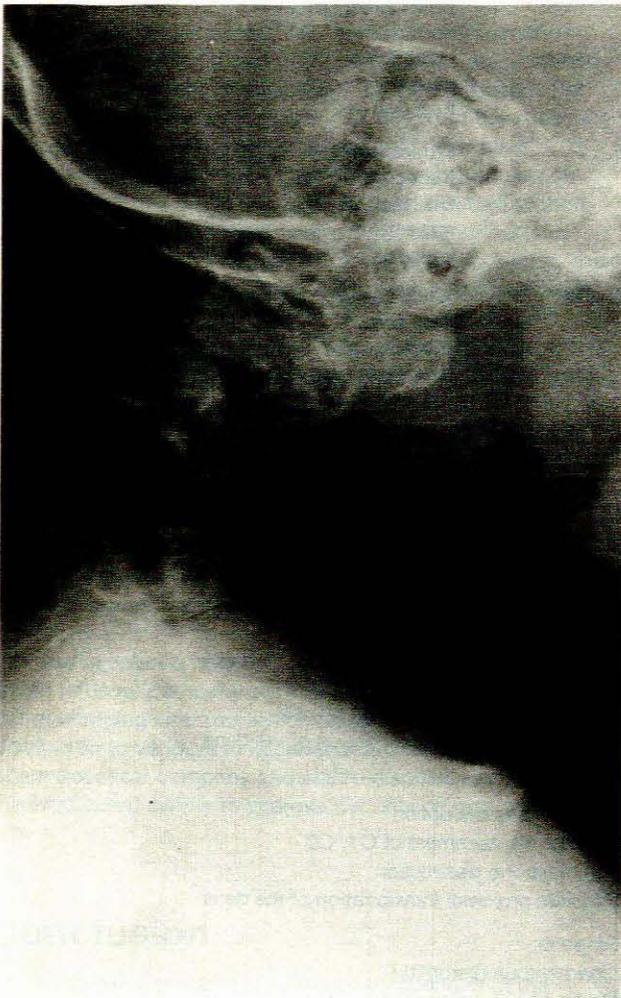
Case 6. Radiograph showing severe prevertebral soft-tissue swelling. Note that C4, C5 and C6 are involved.
